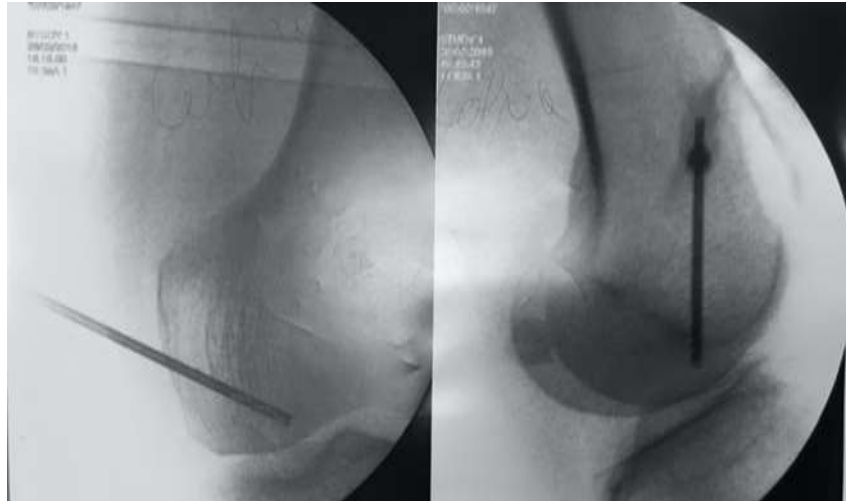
The procedure performed under radioscopic guidance. Images in correspond to Fig 6 MRI, medial femoral condyle subchondral lesion.
